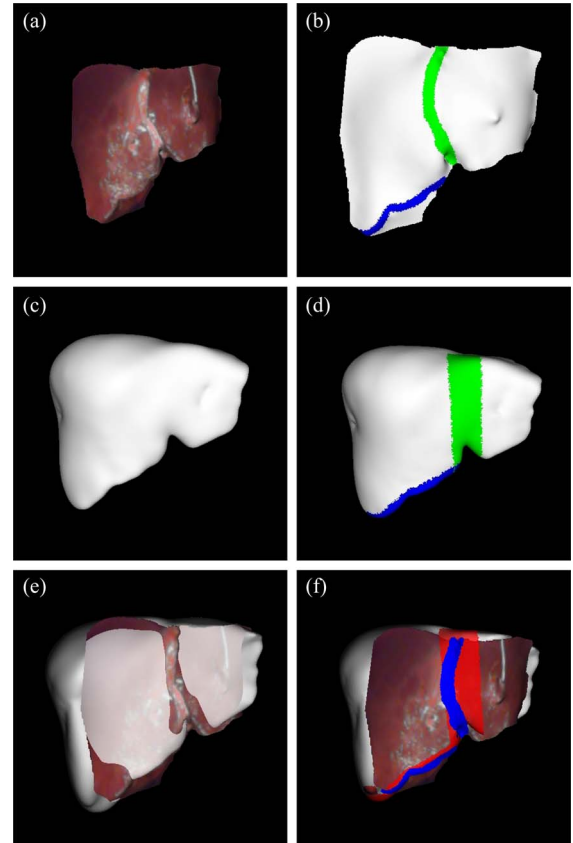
LRS surface data (a)–(b), CT surface data (c)–(d) and resulting weighted patch ICP registration (e)–(f) for case 8. The segmentations of the patch regions are shown for the LRS and CT surfaces in panels (b) and (d), respectively. The falciform region is highlighted in green, while the inferior ridge of segments IV, V, and VI is shown in blue.
